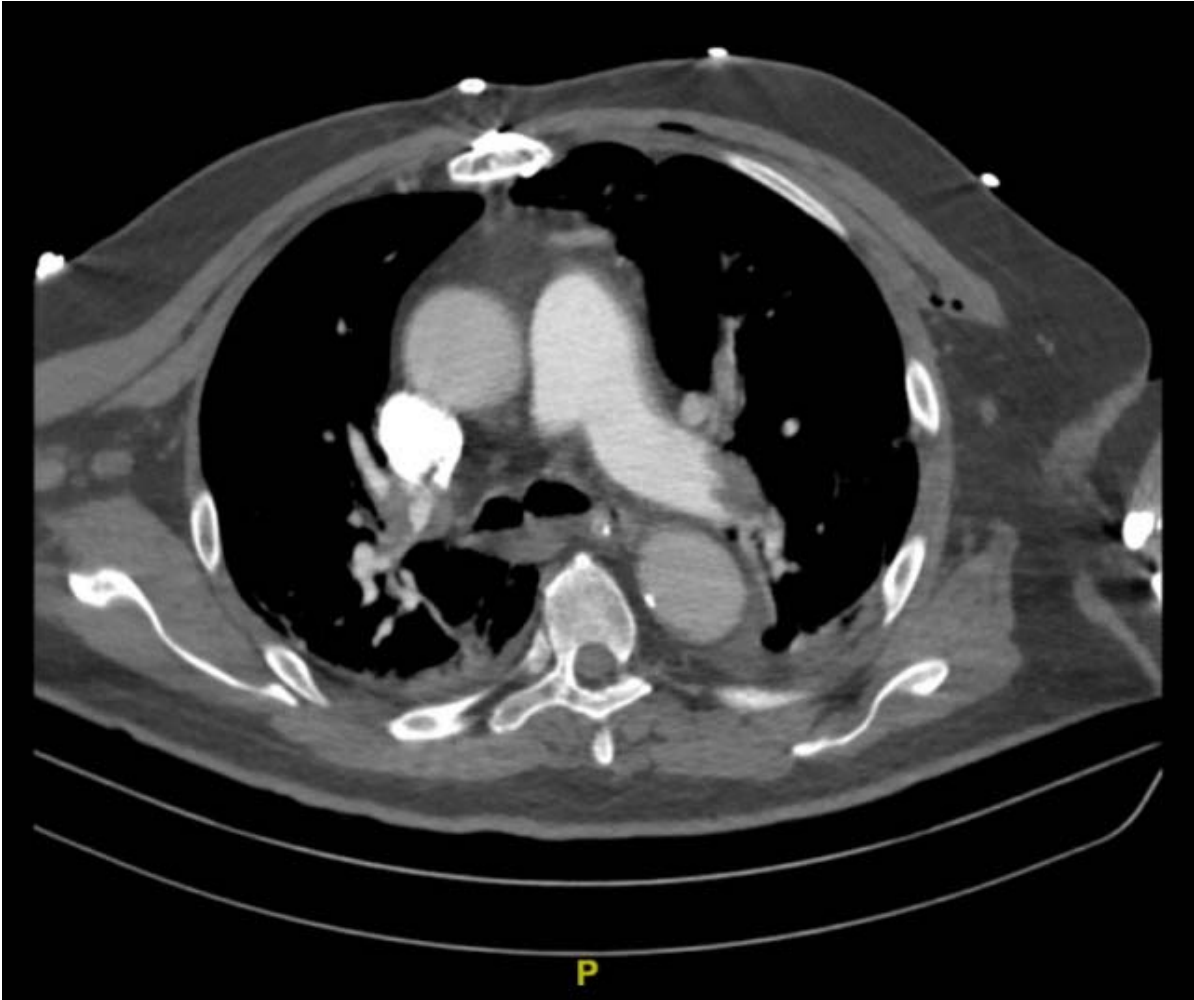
Contrast-enhanced CT showing the pulmonary embolus
